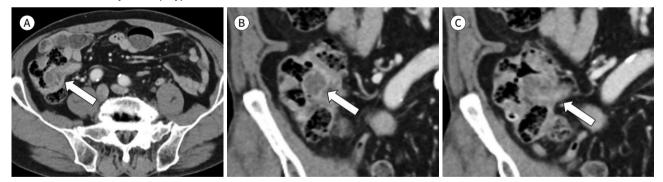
Inflammatory fibroid polyp in a 79-year-old male incidentally detected during ileocolonoscopy and CT, and surgically confirmed. A-C. Axial (A) and coronal (B, C) contrast-enhanced CT images show a 2.5 cm polypoid nodule at the ileocecal valve (arrows), initially suggesting GIST or leiomyoma. The patient underwent ileocecectomy, and the lesion was finally diagnosed as an inflammatory fibroid polyp. After second image review, our case showed a poorly enhancing mass with overlying mucosal hyperenhancement, which is a common feature of inflammatory fibroid polyps.
